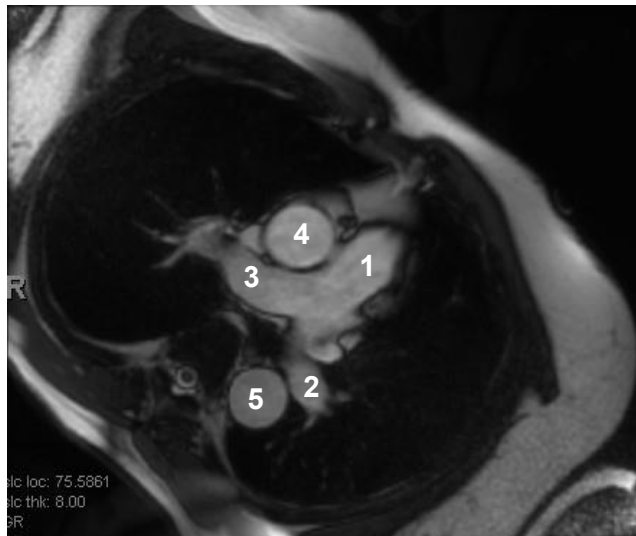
MRI of the pulmonary arteries and aorta.
